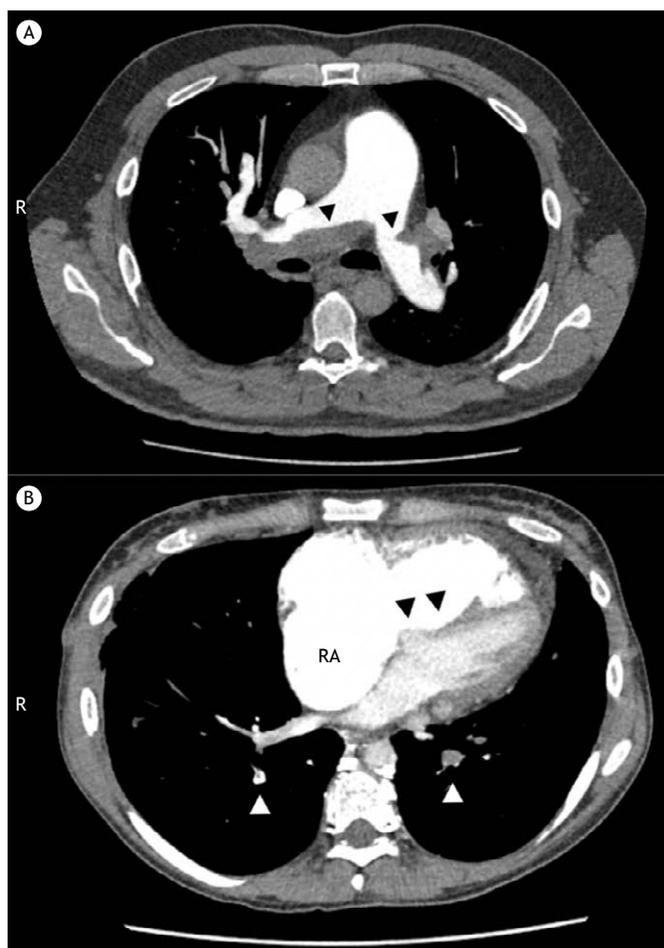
Chest CT angiography of a patient with chronic thromboembolic pulmonary hypertension. Note in A the eccentric clots that adhere to the pulmonary artery walls; in B, in addition to the clots, the dilated right atrium (RA) and the flattening of the interventricular septum (black arrowheads), suggesting pulmonary hypertension and right ventricular dysfunction.
